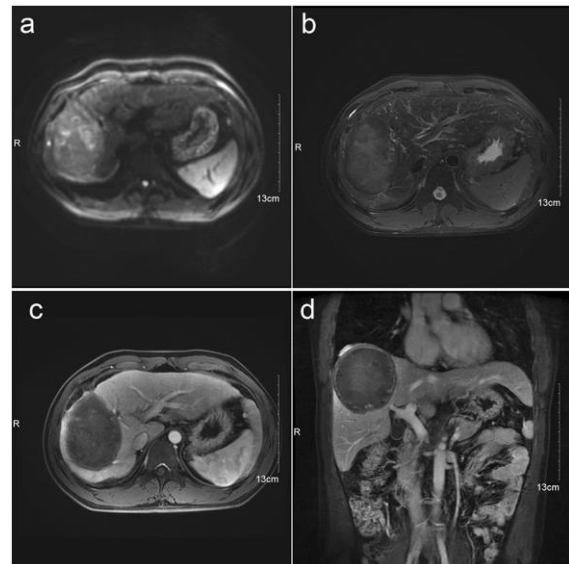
Patient B treated with TILA-TACE. Liver contrast-enhanced MRI images 20 months after the second session of treatment show a stable complete necrosis of the treated tumor. (a) DWI. (b) T2WI. (c) Axial, T1WI with contrast-enhanced MRI, arterial phase. (d) Coronal, T1WI with contrast-enhanced MRI, arterial phase.
